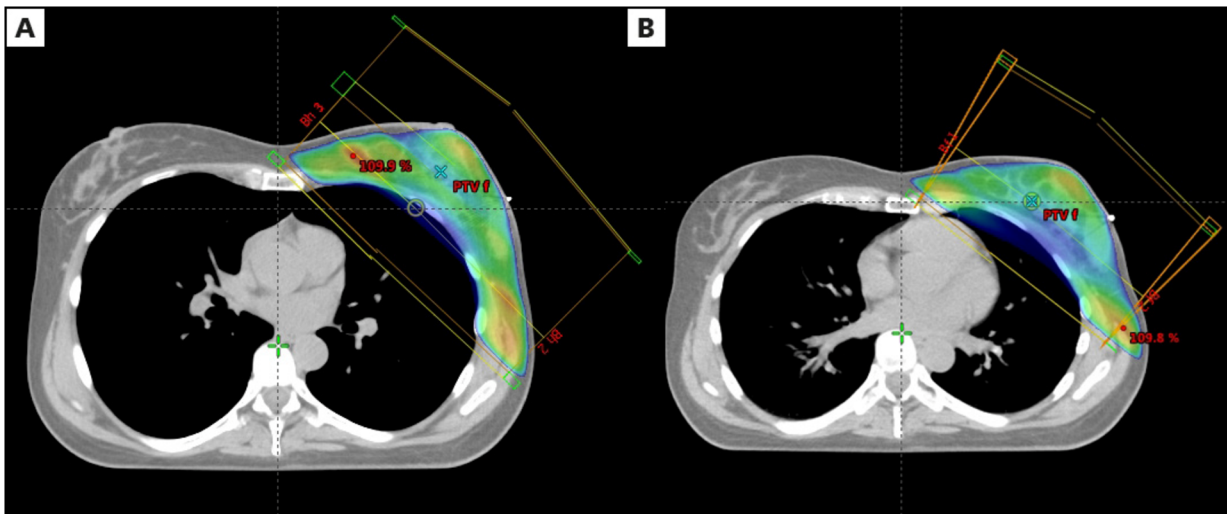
Axial views of computed tomography (CT) based radiation free breathing (FB) (A) and deep inspiration breath-hold (DIBH) (B) plans. The area in colour-wash represents volume covered by 95% isodose
